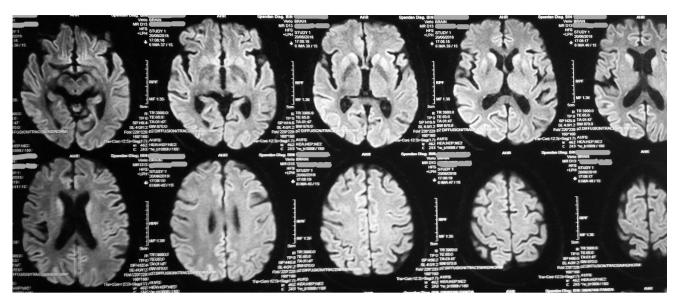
Patient's MRI. Bilateral caudate nucleus and putamen hyperintensity is observed, as well as multiple cortical areas resembling ribbon pattern.
